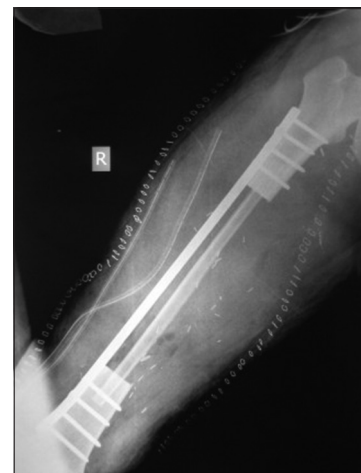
Post-operative X-ray showing free fibula bridging the gap of the resected tumour-bearing femur
